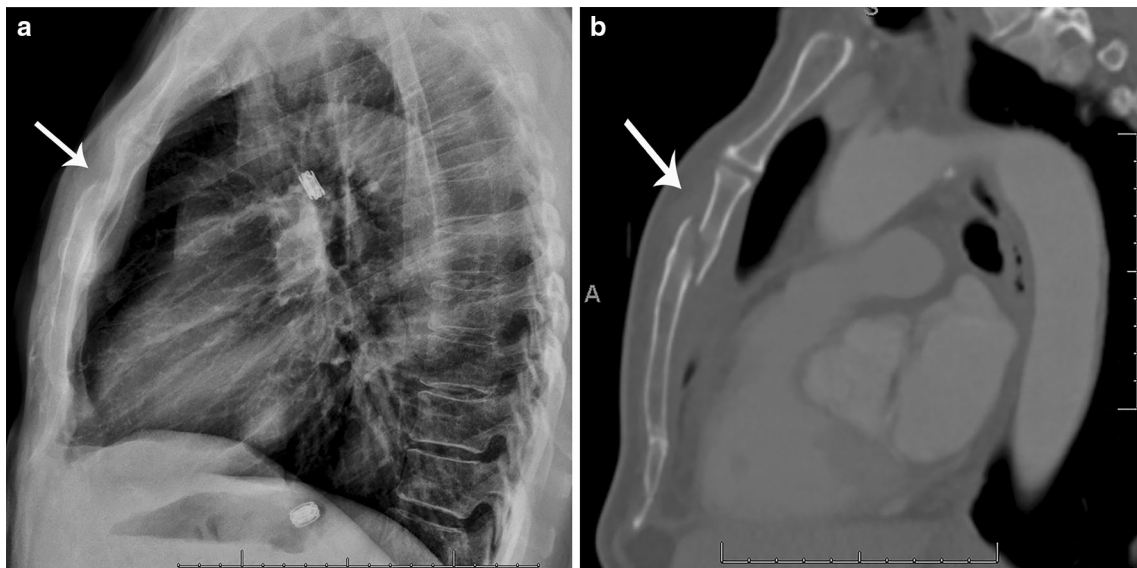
Sternal fractures can be missed on radiograph and on CT if the sternum is not carefully inspected. Without dedicated sternal views, the lateral chest radiograph (a) can reveal the presence of a sternal fracture by following the anterior and posterior cortex looking for discontinuity (arrow) and retrosternal soft tissue attenuation from
